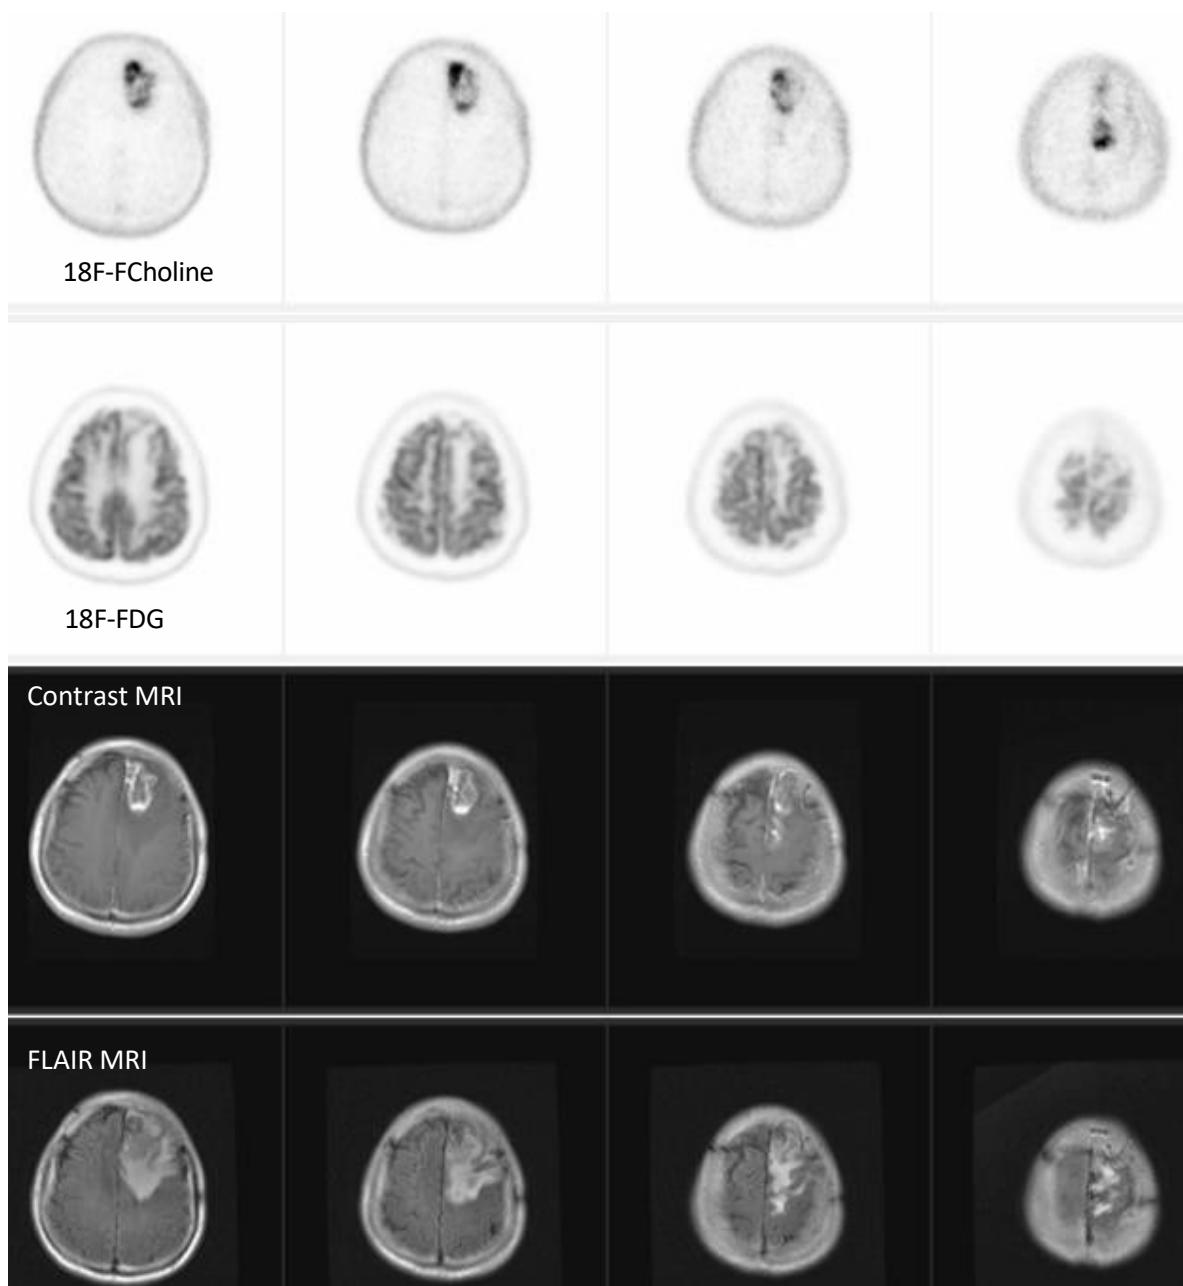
A patient at MSKCC with an evolving brain lesion following stereotactic radiosurgery for a left frontal lobe lung adenocarcinoma metastasis. The patient was scheduled for surgical resection based on clinical grounds, prior to enrollment in the 18F-FCholine PET study (protocol 13-199). Panel A shows foci of high 18F-FCholine uptake in the lesion. Panel B shows some irregular 18F-FDG uptake around the lesion (the level of uptake is between cortex and white matter), which is difficult to interpret. The official reading attributed the findings to radiation necrosis and less likely viable tumor. Panel C shows the lesion with irregular contrast enhancement. Panel D shows a FLAIR signal well beyond the margins of contrast enhancement, suggesting the presence of significant brain edema. The official pathologic diagnosis of tissue removed at time of surgery was consistent with metastatic adenocarcinoma.
